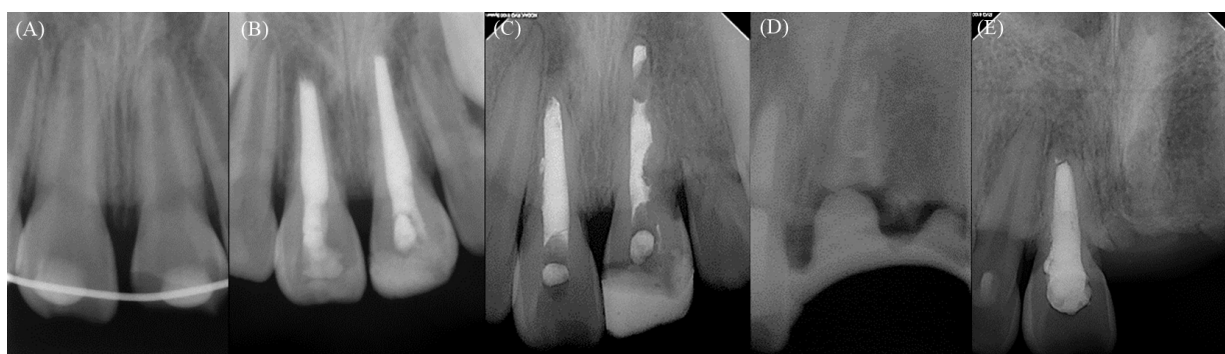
The radiographic view of #21, 22. (A) post replantation; (B) after 4 months of follow-up; (C) after 5 years of follow-up; (D) after decoronation; and (E) after 5 years of decoronation.
